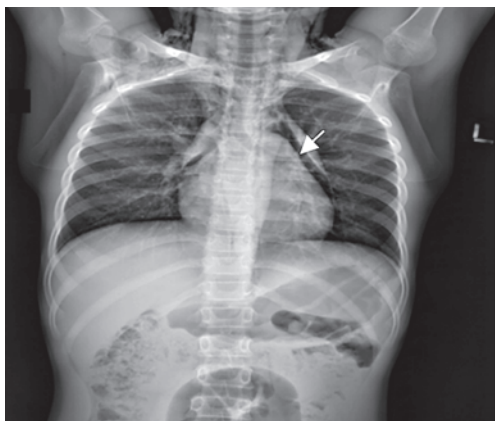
X-ray chest: Spinnaker sail sign
